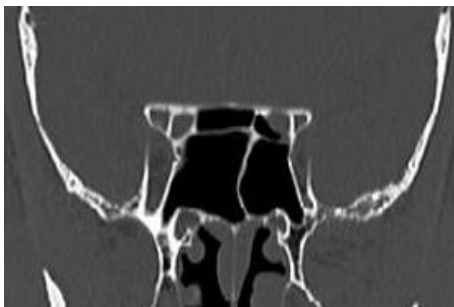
Coronal CT scan showing Onodi cell and type 4 optic nerve on both sides. Left optic canal is showing dehiscence and protrusion into Onodi cell.
